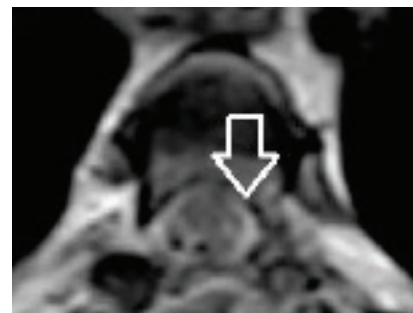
T2-W axial MR images (Post-operative)
